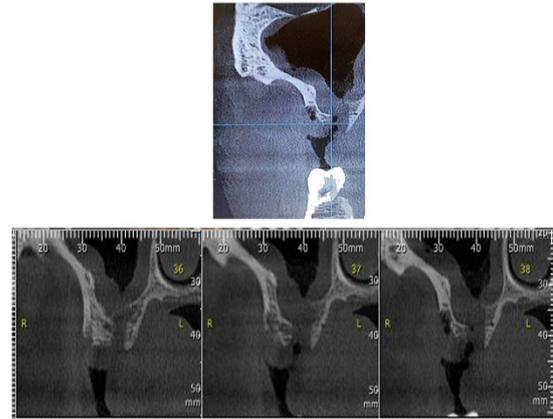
Preoperative computed tomography (C.B.C.T).
